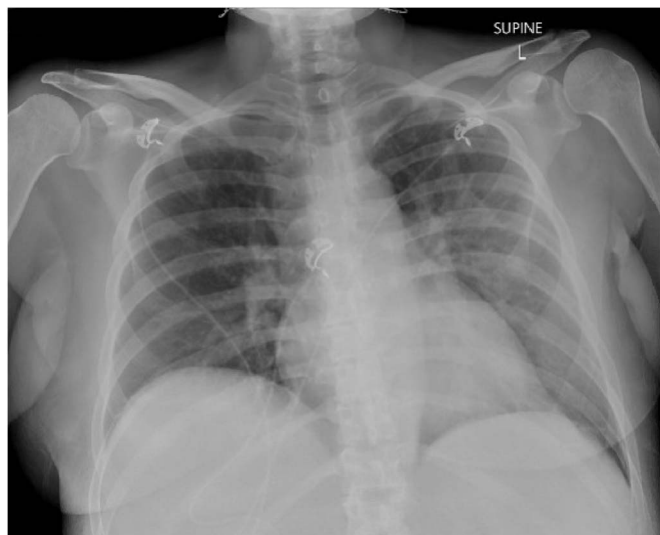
Anterior-posterior thoracic x-ray on admission showing a left perihilar ground-glass infiltrate.
